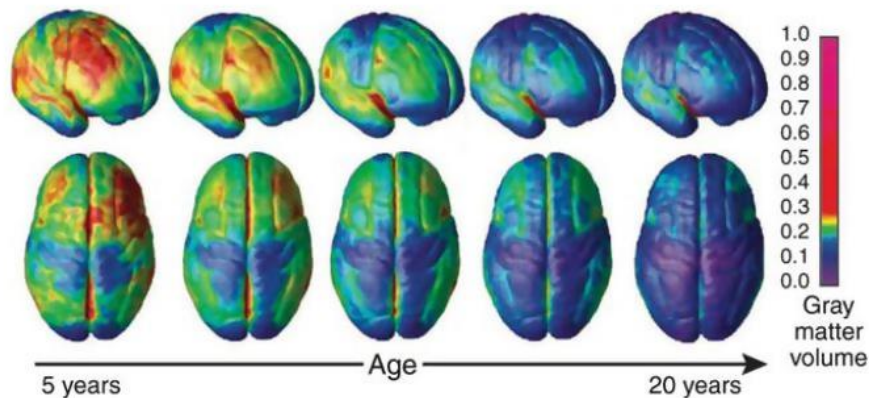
Gray matter maturation across development. This image represents data from 52 anatomical MRI scans from 13 individuals aged 4-21 years, scanned four times at approximately 2-year intervals. Color scale represents gray matter units of volume (reproduced from Gogtay et al., 2004)
